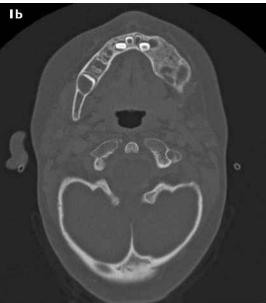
I (a) 3D CT image of the head taken in May 2007 after the biopsy and prior to excision shows an expansile lesion in the body of the mandible extending up into the left ramus. (b) Axial CT image shows that the lesion comprises lucent and sclerotic regions, possibly partly the result of chemotherapy.
